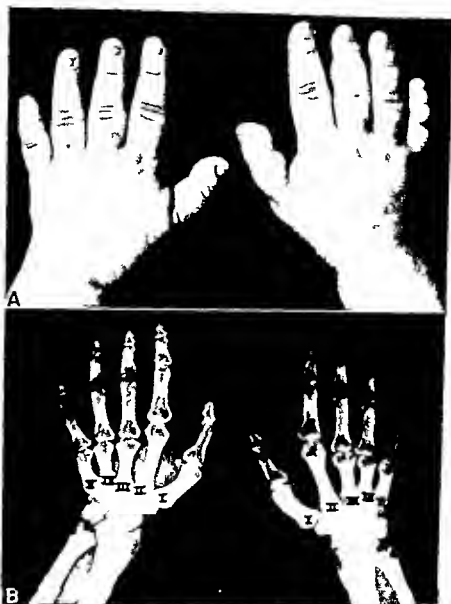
Pseudo hypoparathyroidism. Photograph and X-ray of hands to show short fingers.
